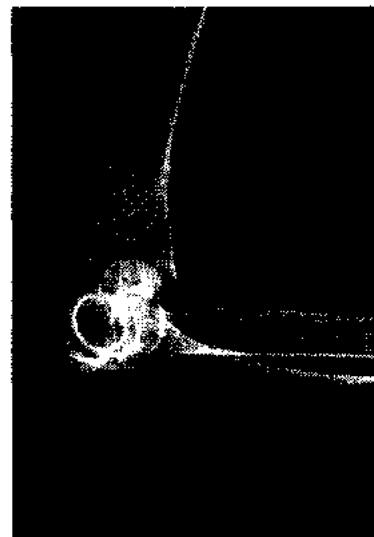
Lateral radiograph of a transcondylar fracture.
